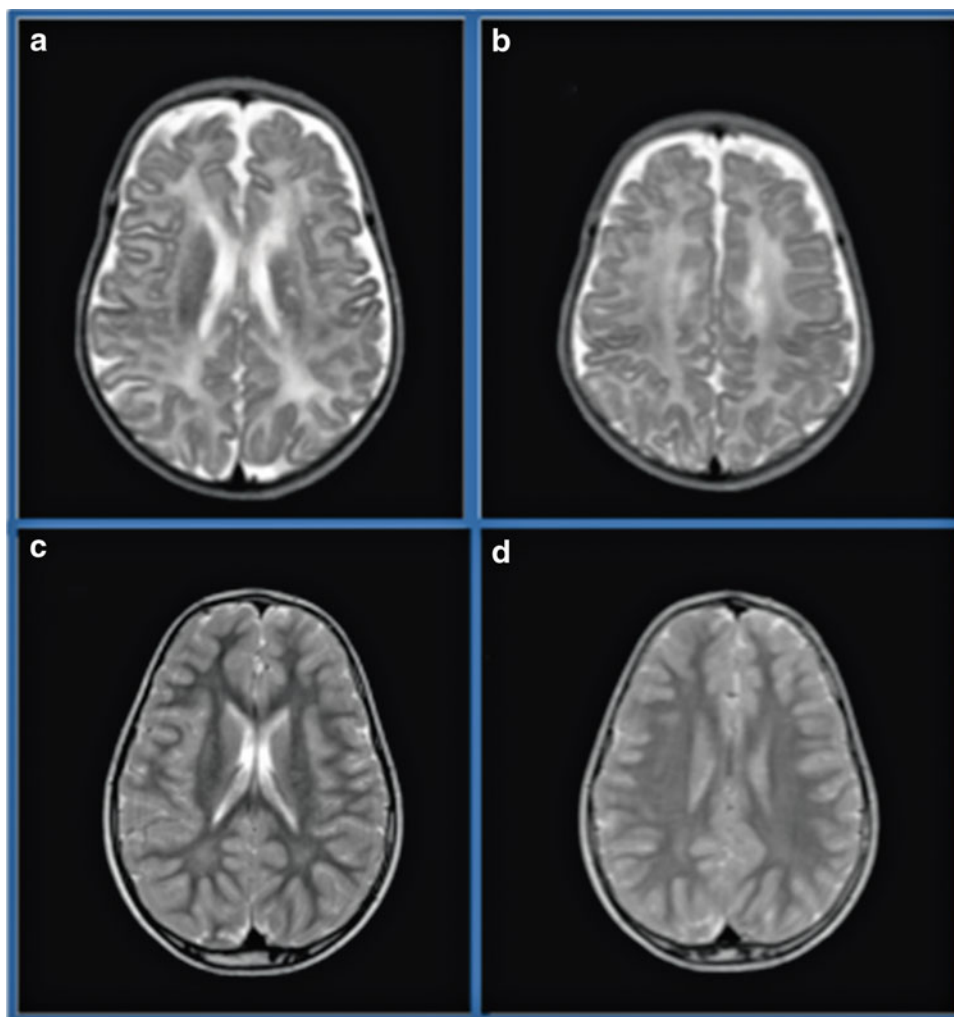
Bilateral hyperintensity of the caudate nuclei in brain MRI at 2 months of life (a, b) and at 7 years (c, d). The hyperintensity of the heads (a) and the tails of the caudate nuclei (b) is absent at the age of 7 years (c, d)
